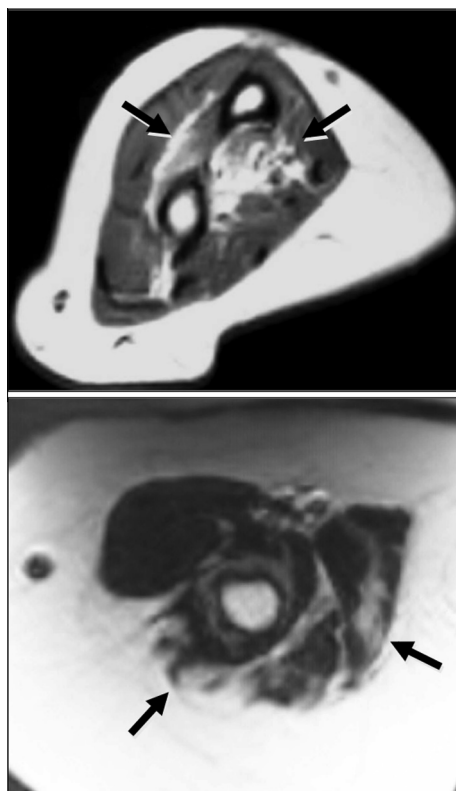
Axial protein density weighted MRI images of the upper limbs in two patients with longstanding IBM showing hyperintensity in the deep finger and wrist flexors (top), and in the triceps muscle complex (bottom) in keeping with fatty infiltration.
